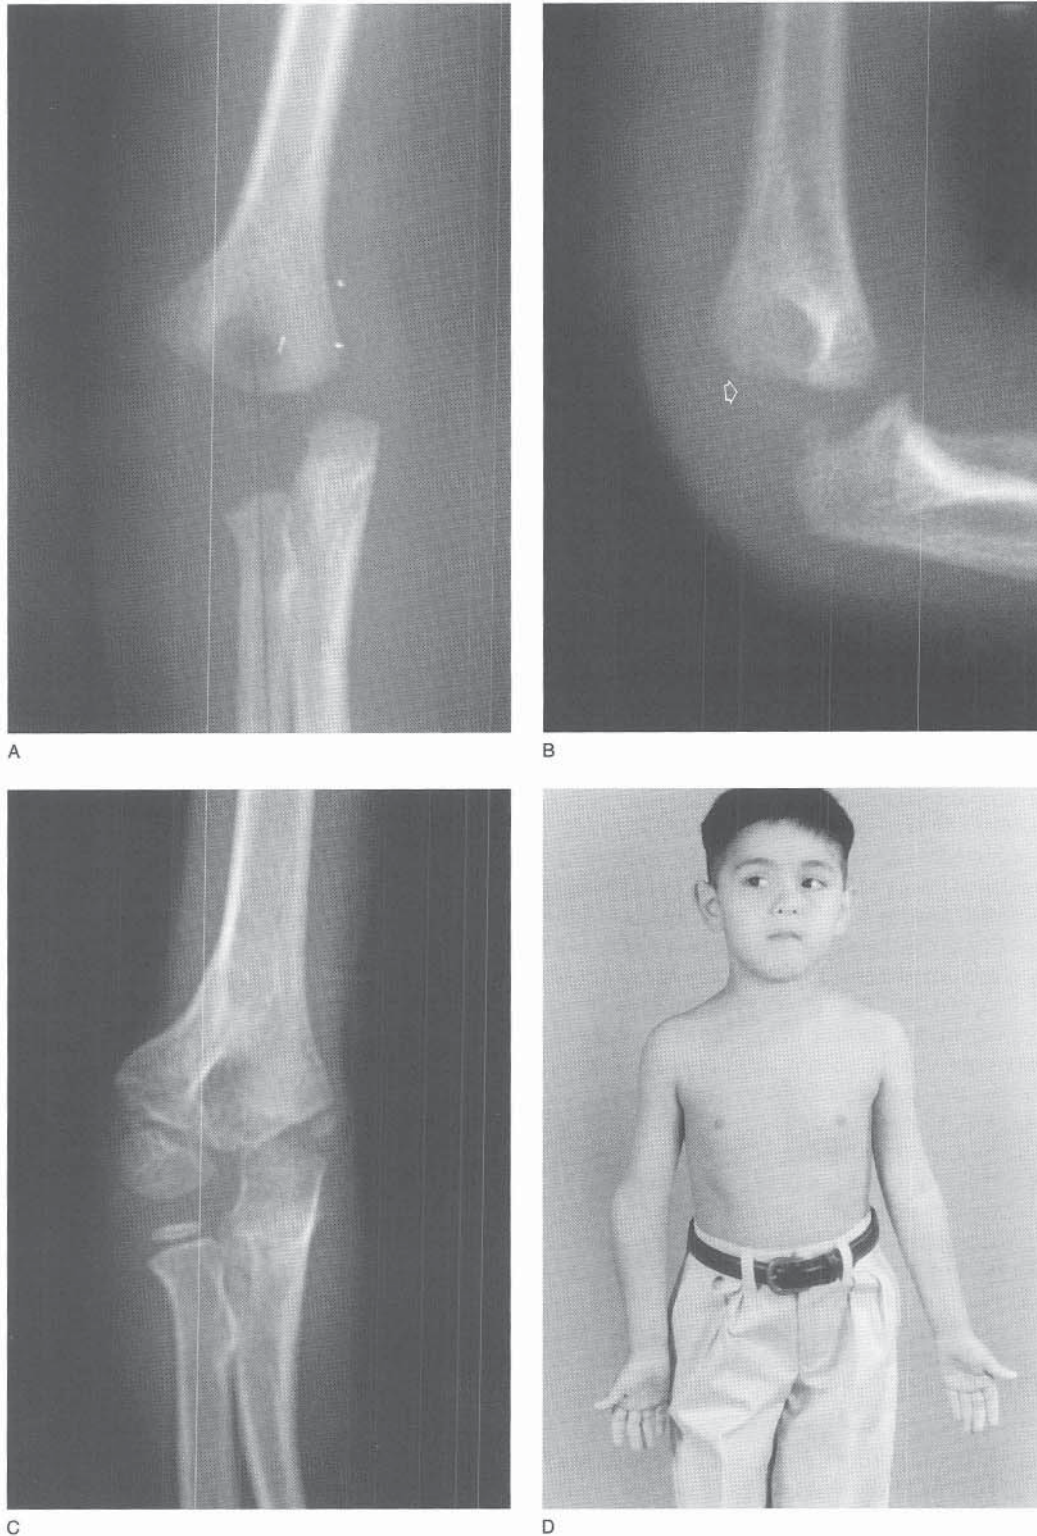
A, AP radiograph of transphyseal separation of the distal humerus. The medial translation of the forearm gives the appearance of an elbow dislocation; however, the radius and capitellum remain congruent. B, Lateral radiograph of transphyseal separation. Note the small posteriorly based metaphyseal (Thurston-Holland) fragment (*arrow*). The patient was treated with closed reduction and cast immobilization. C, AP radiograph 3 years after injury shows varus malunion. D, Clinical appearance 3 years after the injury.
